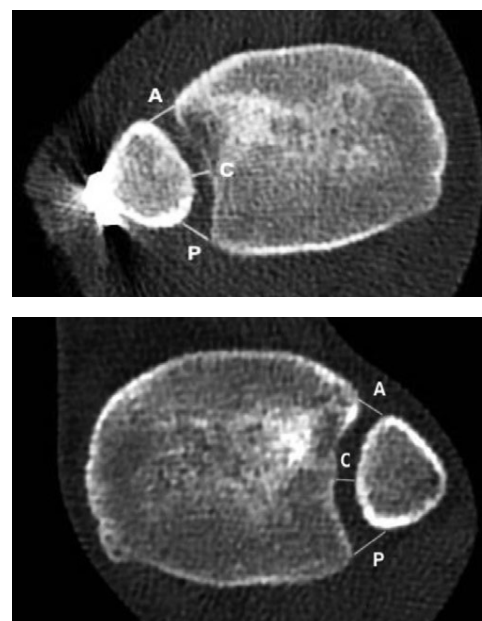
CT of injured ankle (upper panel) and uninjured ankle (lower panel) in a 20-year-old woman, 2 years after injury. Tibiofibular distance is measured on axial CT 1 cm proximal to the ankle joint. Distance measured anterior (A); central (C); and posterior (P).
